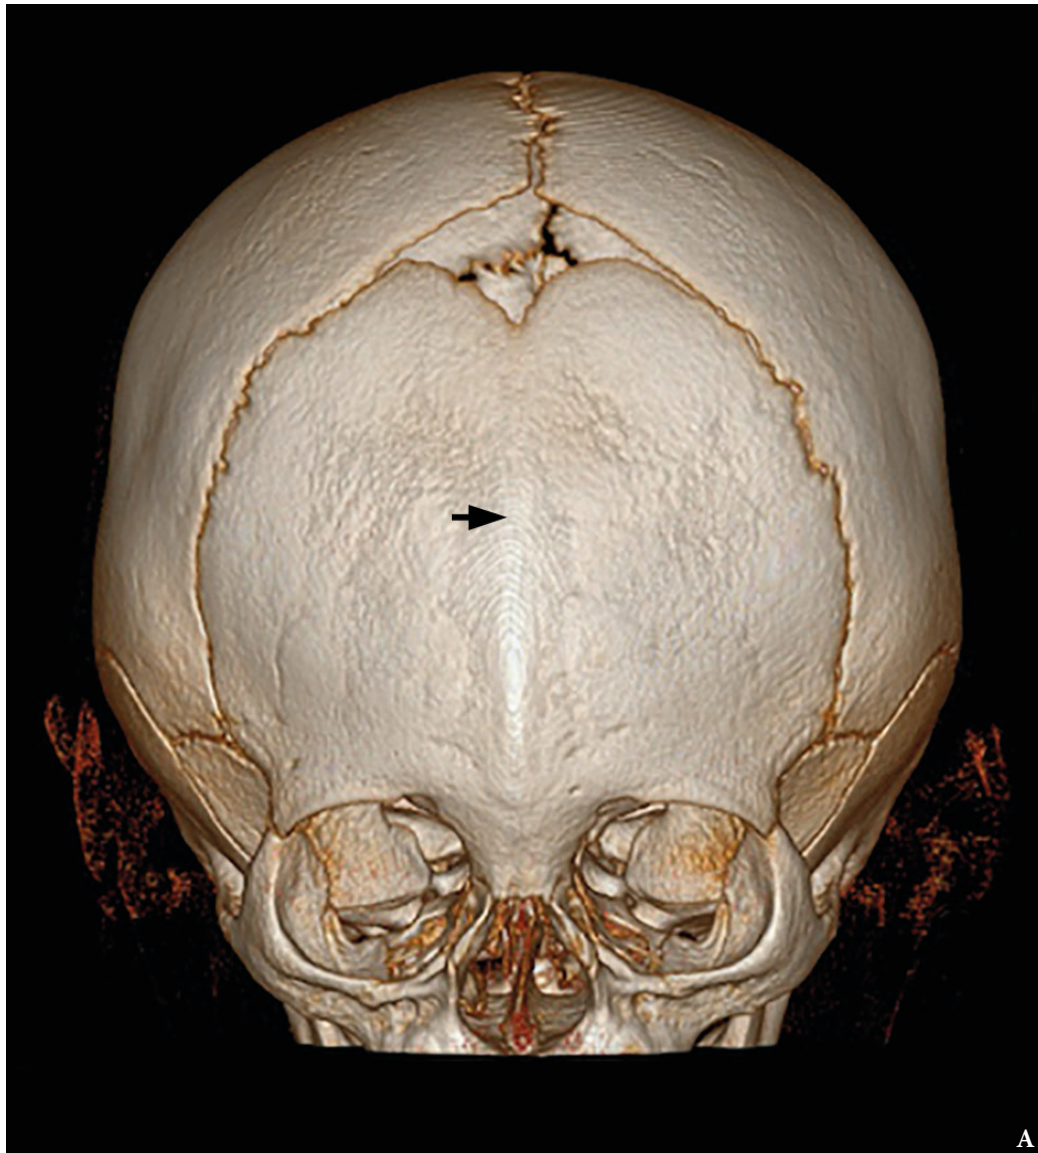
Anterior view (A) of 3D-CT volume-rendered image of a 4-month-old boy, showing premature fusion of the metopic suture (*arrow*) and the consequent triangular shape of the forehead, together with hypotelorism, flattening of the two frontal bones and bossing of the parieto-occipital regions. A wormian or intrasutural bone is present as well in the lambdoid suture. (Fig 2 continued on next page.)
